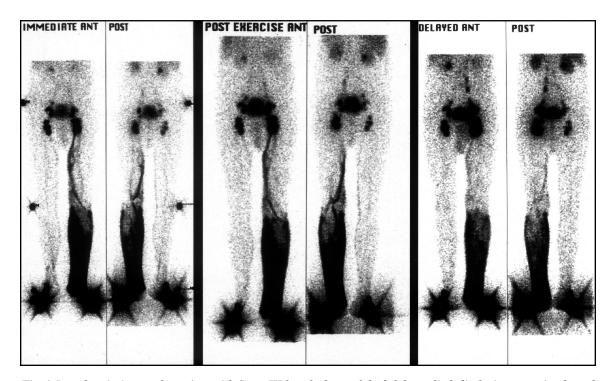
Lymphoscintigram of a patient with Stage III lymphedema of the left lower limb displaying extensive dermal diffusion below the knee. Normal right lower limb.
